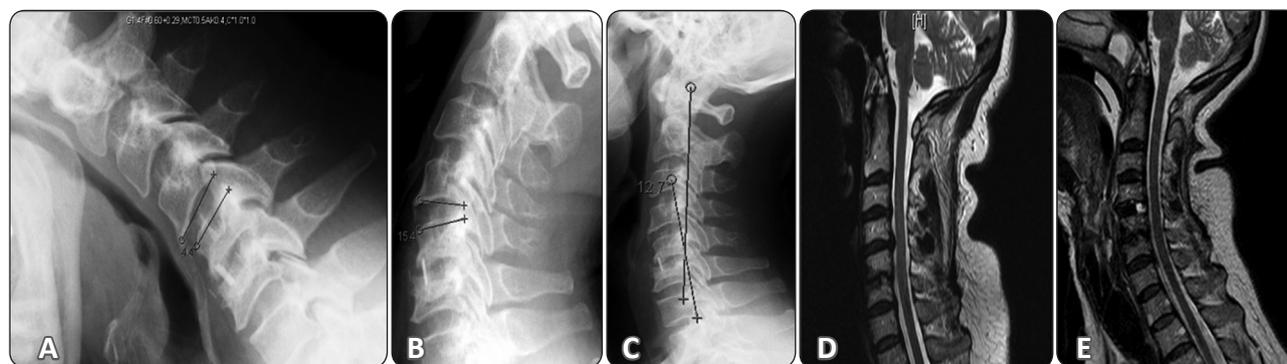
35 years old male operated on by ACDF C5-C6 and affected by ASD after 2 years. Increased range of motion (19.8): (A) flexion angle -4.4 and (B) extension angle 15.4. (C) The Cobb angle showed postoperative good lordotic alignment. (D) Postoperative sagittal MRI showed C4-C5 ASD. (E) The patient needed surgical intervention for that level; sagittal MRI after the second ACDF.
